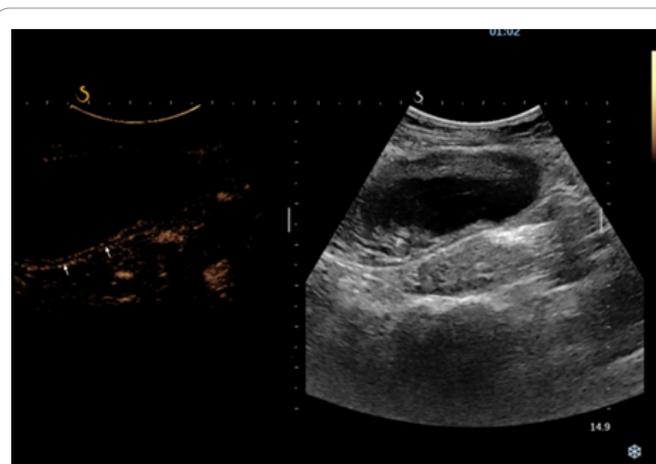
Contrast-enhanced ultrasound at Late phase 62 sec after bolus injection: normal contrast-enhanced wall of the appendix (white arrows). No presence of wash.
